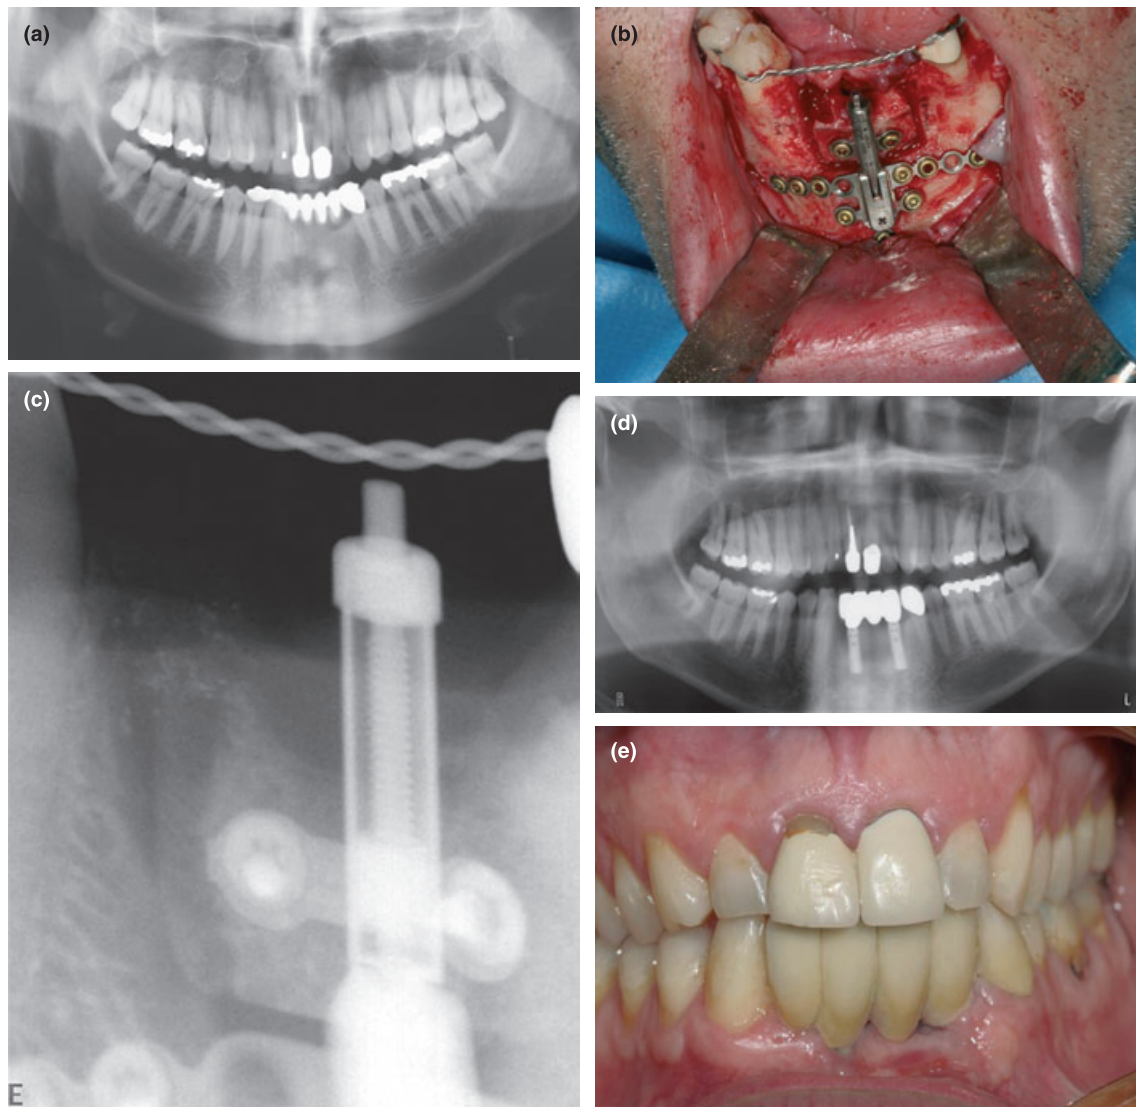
(a) Panorama showing loss four anterior teeth in the mandible following trauma and also loss of bone height; (b) surgical field after osteotomy and placement of the distractor; (c) radiography after completed distraction; (d) implants and fixed bridge; (e) clinical view of fixed bridge.
